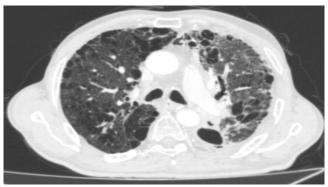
CT upon the completion of the cancer treatment showing the cavity in the left lower lobe and atelectasis
